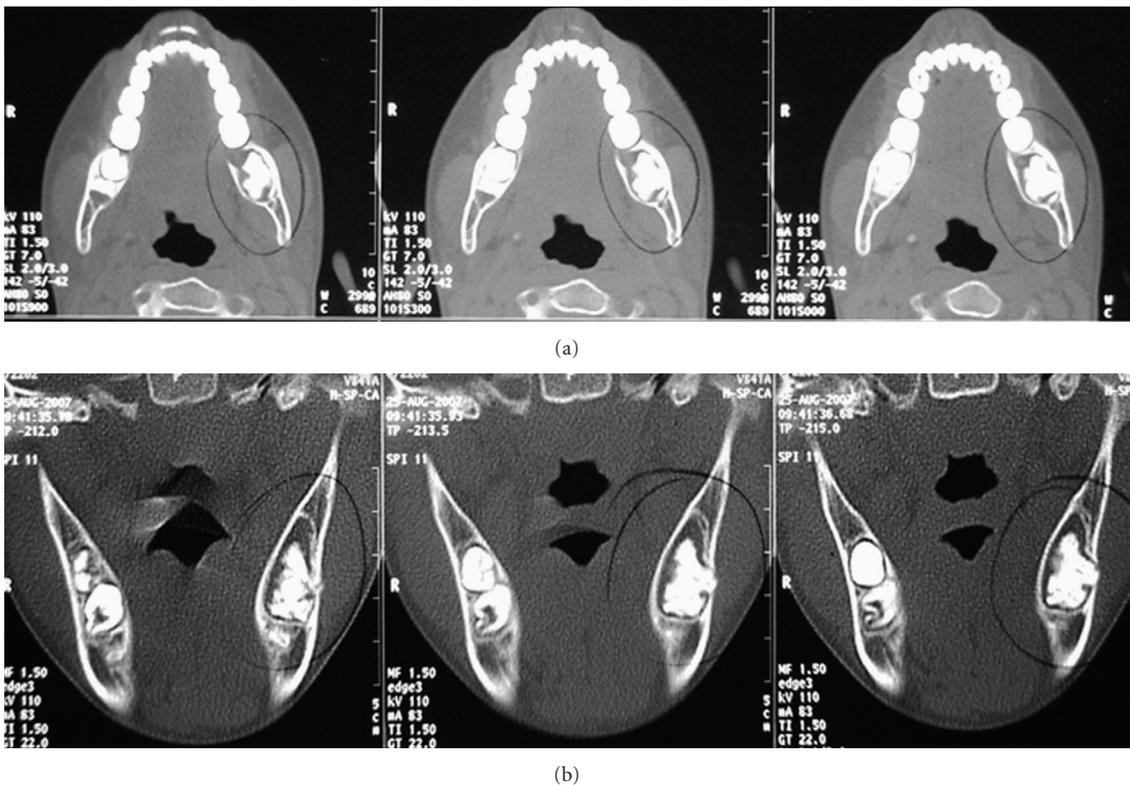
Helical computed tomography images showing an expansile, well-circumscribed lesion containing a calcified mass compatible with odontogenic tissue ((a) axial cuts; (b) coronal cuts).
